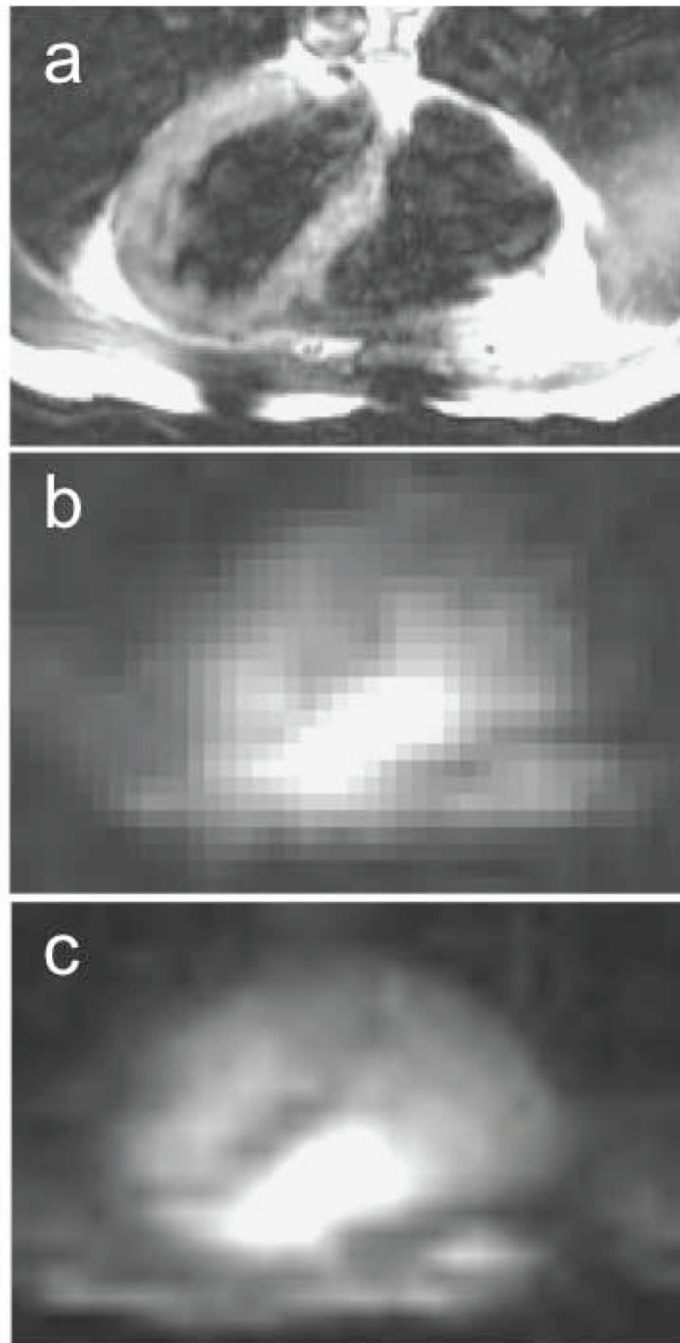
(a) Conventional ^1H trans-axial image, and (b) corresponding single slice ^{23}Na MRI of the human heart acquired with the phased-array in Fig. 2(b) using a slice-selective gradient refocused echo (GRE) sequence in 4s, and (c) 200s (array size, 32×32 ; resolution, $1 \times 1 \times 4 \text{ cm}^3$; TR/TE= 33/5 ms; from Ref. 46).
